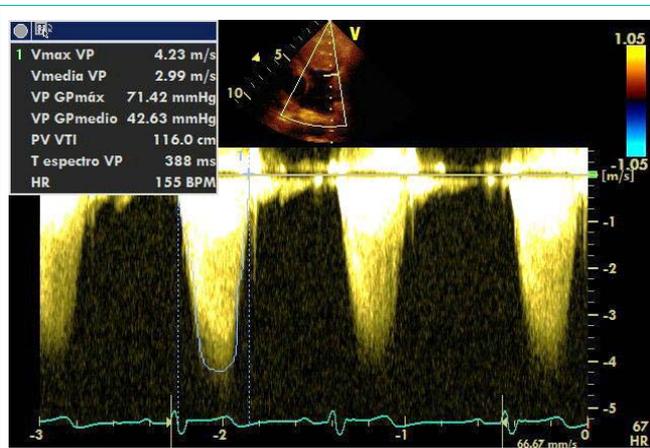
Transthoracic continuous doppler echocardiogram showed severe dynamic obstruction with maximum gradient of 71mmhg.
